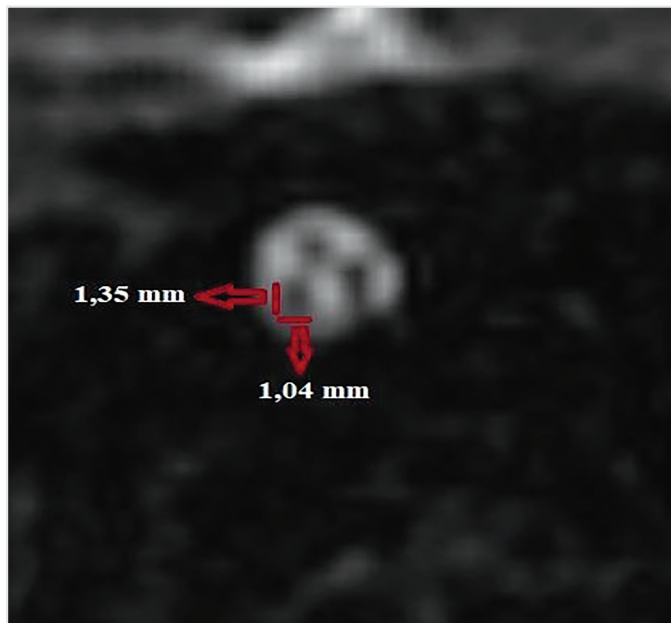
Parasagittal CISS MRI parasagittal images perpendicular to the nerve course at the internal auditory meatus. Measurement of the cochlear nerve (antero-inferior) diameter is demonstrated with the region of interest outlined, and cross-sectional area was calculated
